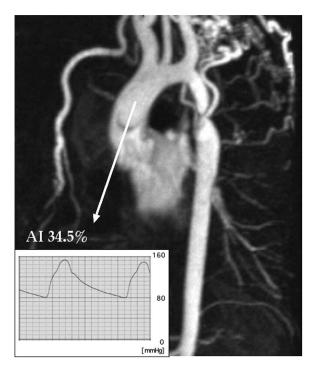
Magnetic resonance imaging and pressure waveform of aorta before balloon angioplasty treatment. AI, augmentation index.
